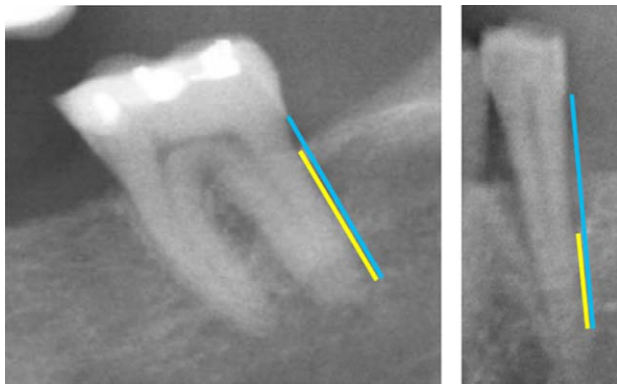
Radiographic measurements were made from the marginal alveolar bone to the tooth apex (yellow line) and from the cemento-enamel junction to the tooth apex (blue line). The examples show the left normal bone height and the right alveolar bone loss.
